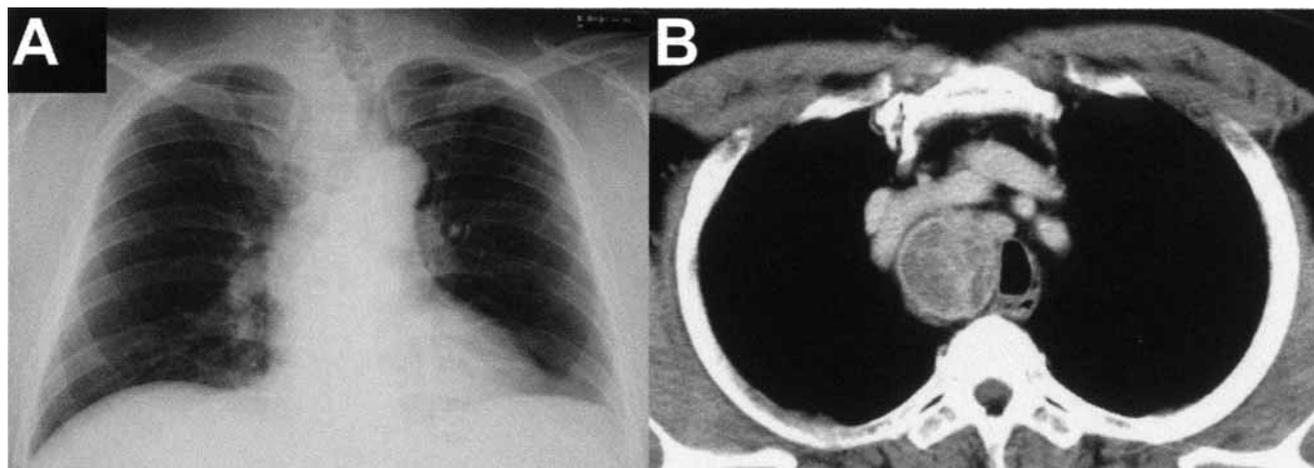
Mediastinal mass posterior to the large vessels and tracheal deviation to the left side are shown in the chest roentgenogram (A) and CT (B) on admission.
